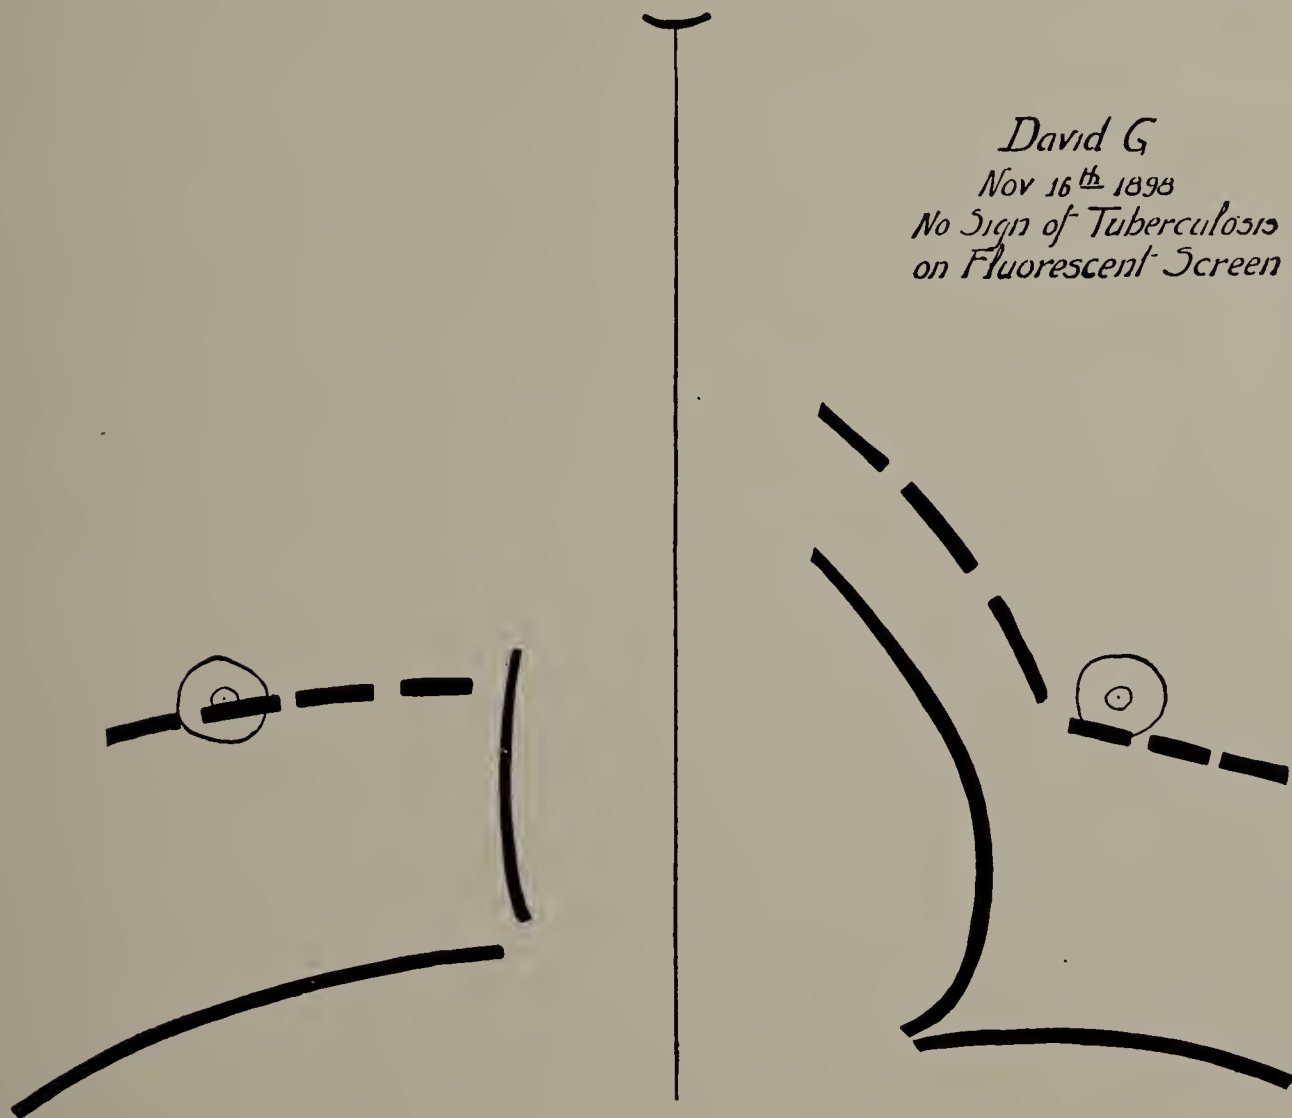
David G. November 16, 1899. X-ray tracing. (One-third life size.) Good appearance of lungs on both sides. Excursion of diaphragm on right side, 7 centimetres; on left side, 6.5 centimetres.
